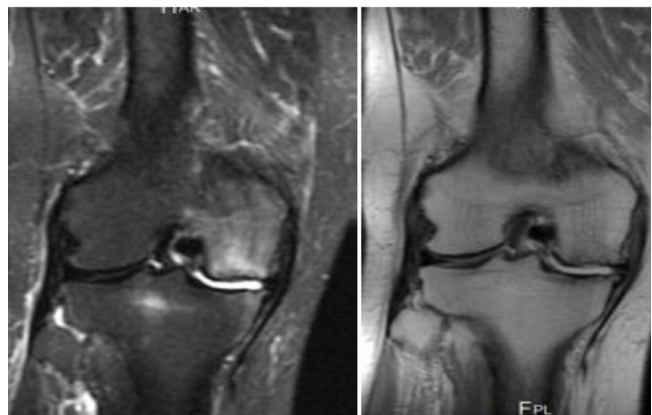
(a) Coronal T2- and (b) T1-weighted magnetic resonance images showing a focal subchondral patch of decreased bone marrow signal on the T1-weighted image and a high signal on the T2-weighted image of the medial femoral condyle, which indicate bone marrow edema. Irregularity of the articular surface, with a subtle depression of the articular surface and signal alteration, was observed.
